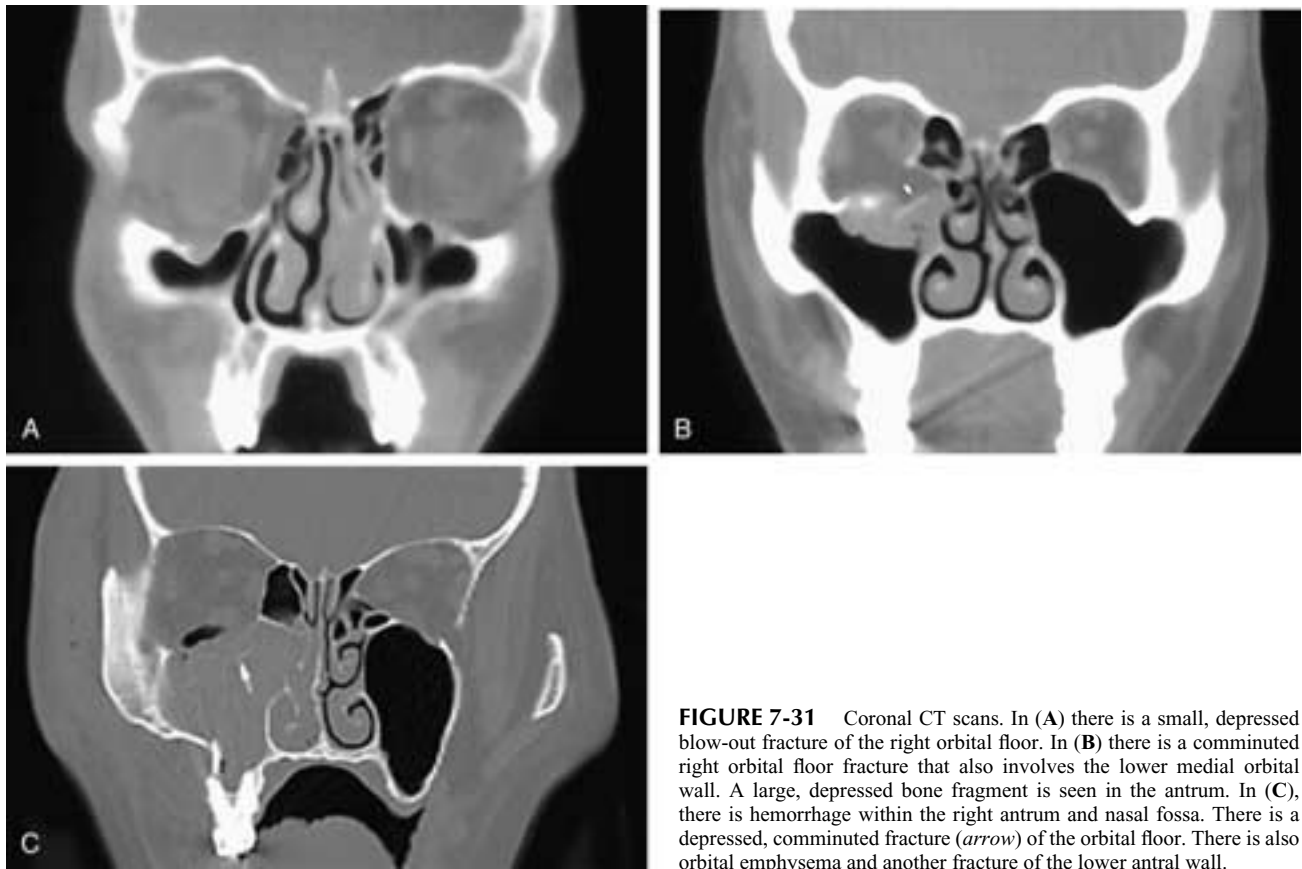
Coronal CT scans. In (A) there is a small, depressed blow-out fracture of the right orbital floor. In (B) there is a comminuted right orbital floor fracture that also involves the lower medial orbital wall. A large, depressed bone fragment is seen in the antrum. In (C), there is hemorrhage within the right antrum and nasal fossa. There is a depressed, comminuted fracture (*arrow*) of the orbital floor. There is also orbital emphysema and another fracture of the lower antral wall.
